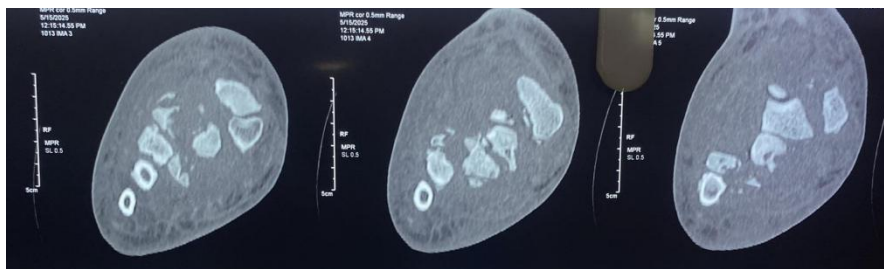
Preoperative CT scan (sagittal reconstruction) showing subchondral sclerosis and structural disorganization producing a destructive post-traumatic pattern.
